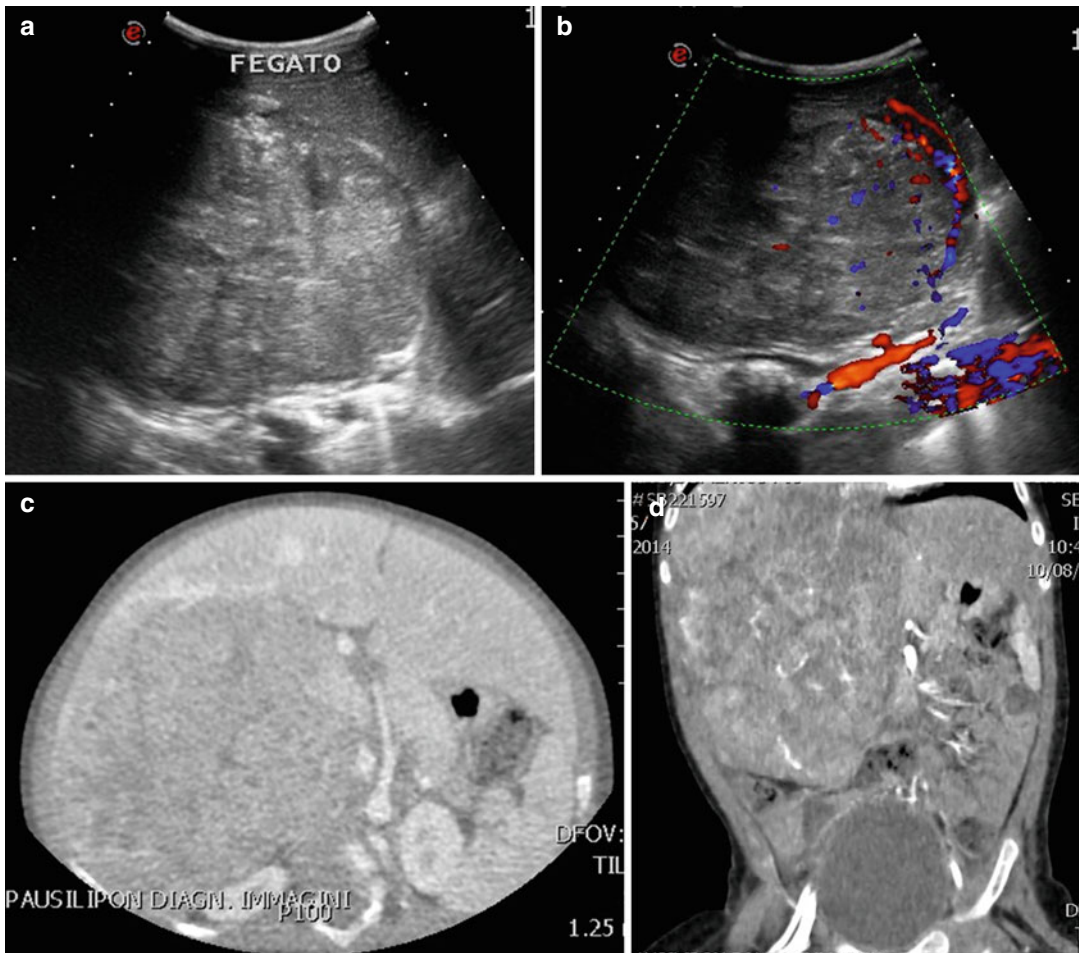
Male, 2 years old. Child with an abdominal palpable mass and distension. US (a, b) shows a heterogeneous hyperechoic right hepatic mass, with intralesional vessel signals at colour Doppler exam (b). MDCT axial
